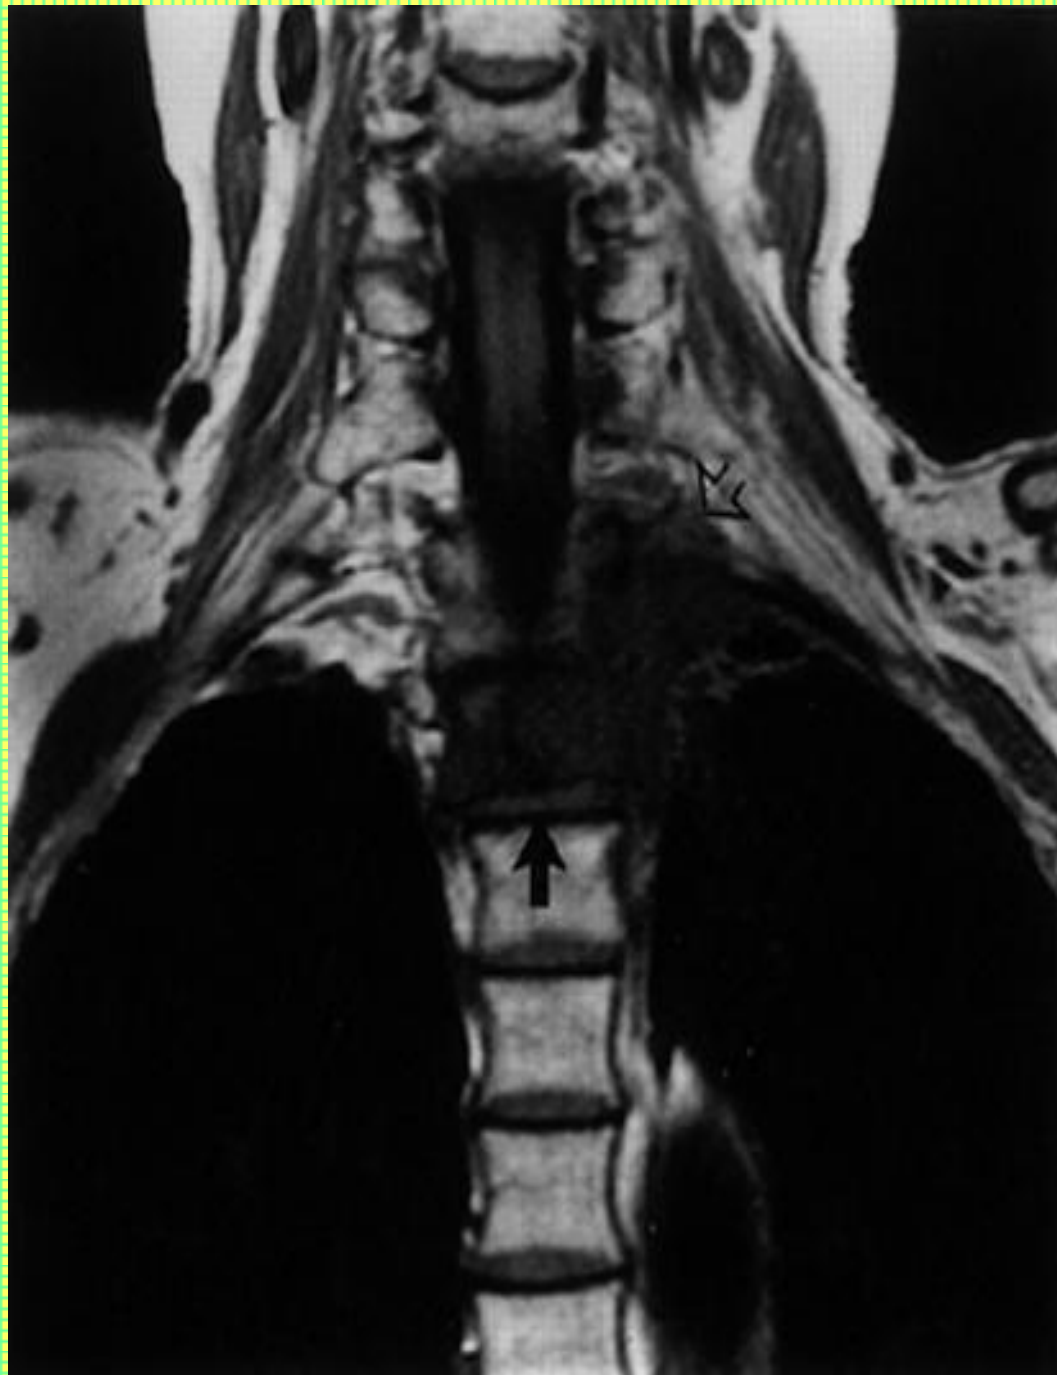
Coronal T1-weighted magnetic resonance imaging showing subtle Pancoast tumour (open arrow) with extension into the superior sulcus and erosion of the adjacent vertebral body (arrow).
